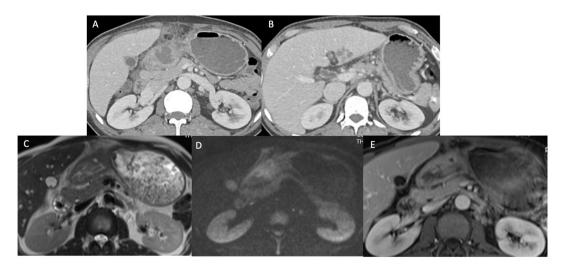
Gastric tuberculosis. A and B) Contrast-enhanced CT demonstrates diffuse irregular thickening of the antrum of the stomach with surrounding fat stranding. Mild proximal dilation of stomach could be suggestive for gastric outlet obstruction. Small multi-loculated abscess is identified in the left lobe of the liver. C) T1weighted MRI redemonstrates the diffuse irregular thickening of the gastric wall with surrounding inflammatory changes, D) diffusion restriction and E) postcontrast enhancement.
